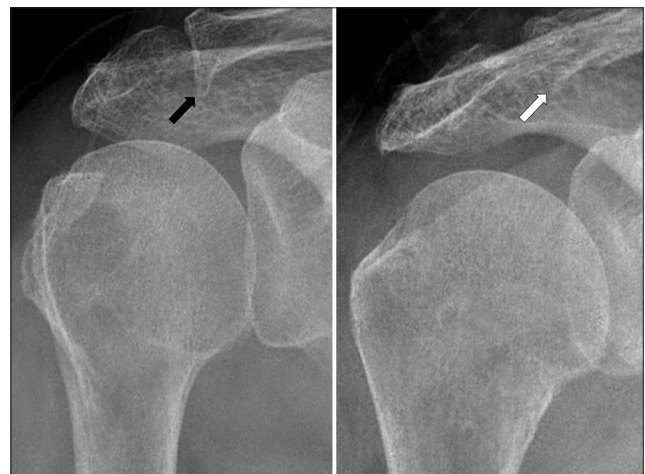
Roentgenogram shows the spur in the distal clavicle before the operation (left: Black arrow), which is completely removed after the operation (right: White arrow)
